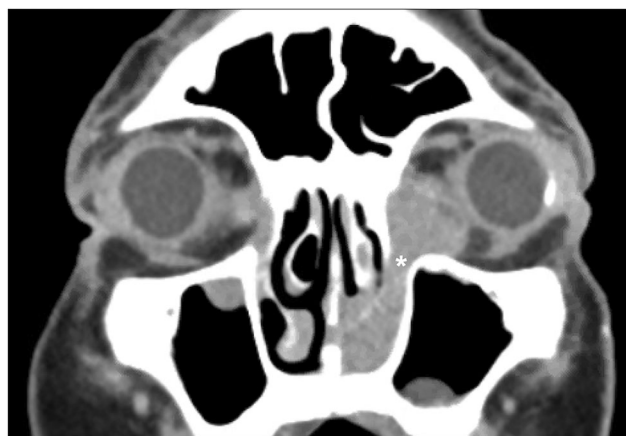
A coronal view on computed tomography of the face, demonstrating squamous cell carcinoma originating in the left nasolacrimal duct (asterisk) and extending into the ipsilateral medial orbit and ipsilateral nasal cavity
